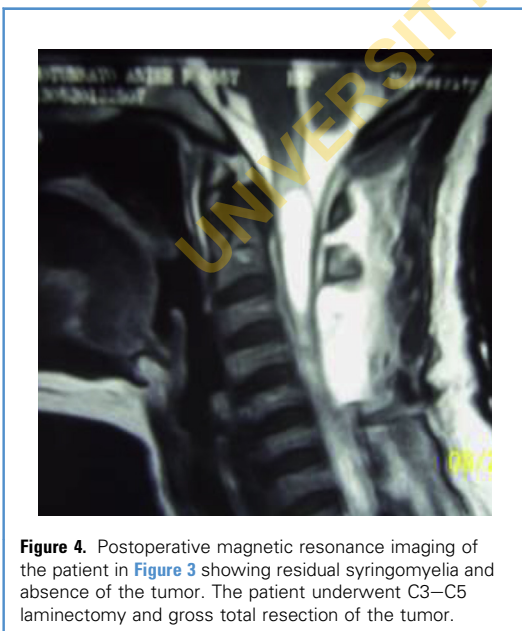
Postoperative magnetic resonance imaging of the patient in Figure 3 showing residual syringomyelia and absence of the tumor. The patient underwent C3–C5 laminectomy and gross total resection of the tumor.
